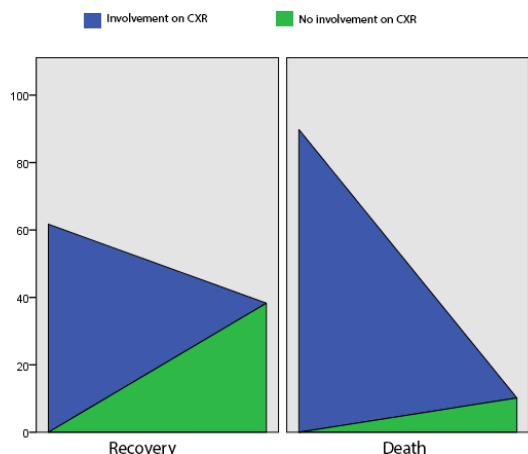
Comparison of different implications in chest radiography.
